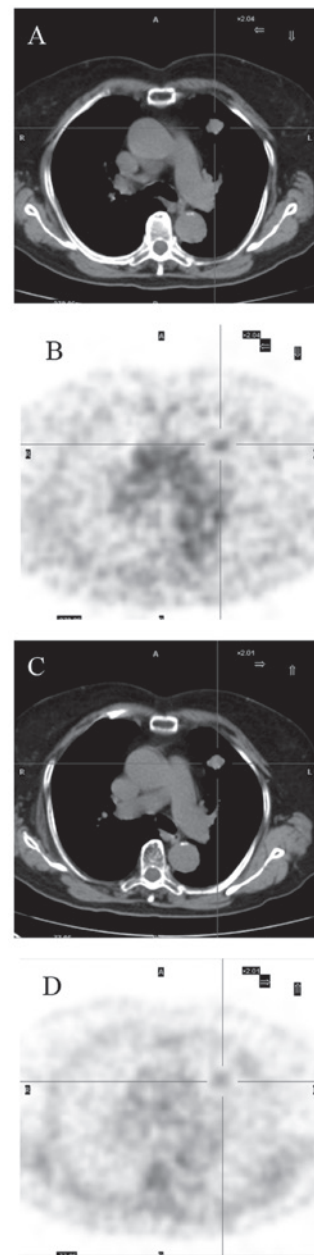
(A) Positron emission tomography/computed tomography revealed a slightly lobulated mass in the left upper lobe of the lung that was ~1.9 cm in diameter and well-defined, with involvement of the mediastinal pleura. (B) Slight uptake of ¹⁸F-fluorodeoxyglucose was also detected. (C and D) Delayed scanning demonstrated that the lesion possessed diminishing metabolism.
